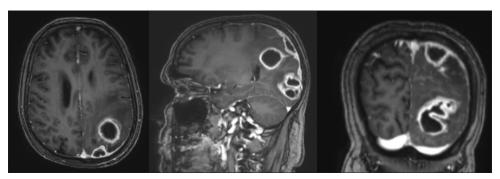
Contrast-enhanced magnetic resonance imaging brain showing multiloculated ring-enhancing lesion in the left parieto-occipital region
